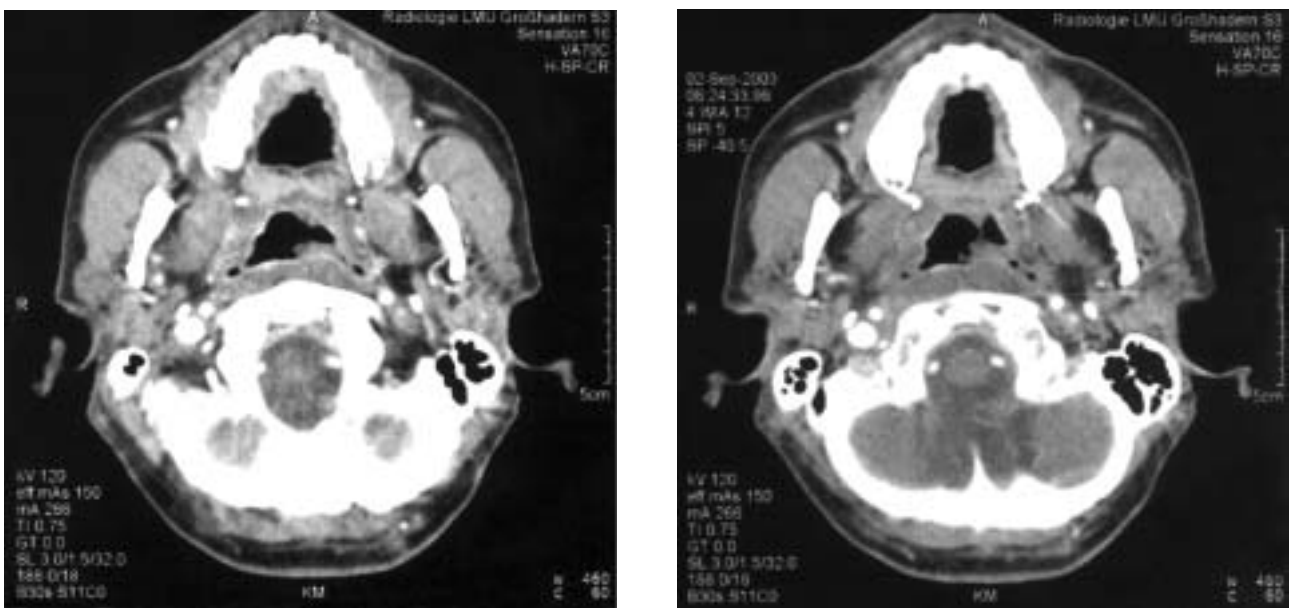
(A, B) A contrast-enhanced CT scan revealing prominent lymphoid tissue in the nasopharynx. Adjacent to the left tube, an exophytic mass is obvious.
